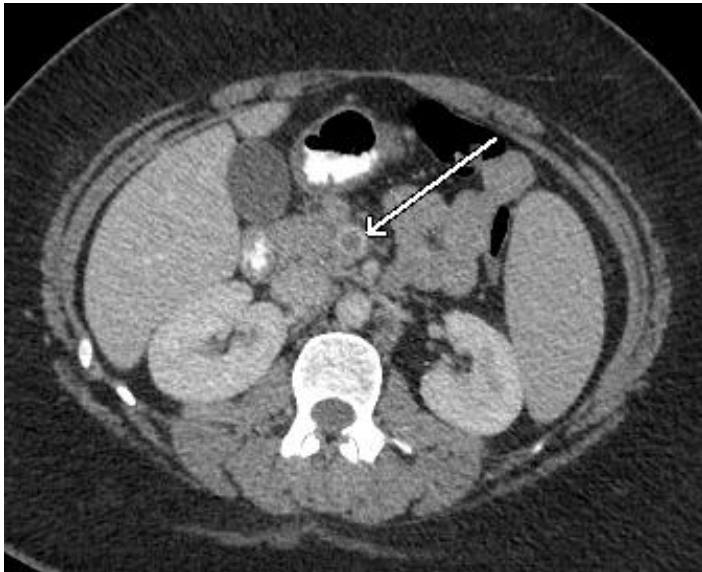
Computed tomography of the abdomen showing a large filling defect in the superior mesenteric vein (arrow) indicating the presence of thrombus.
